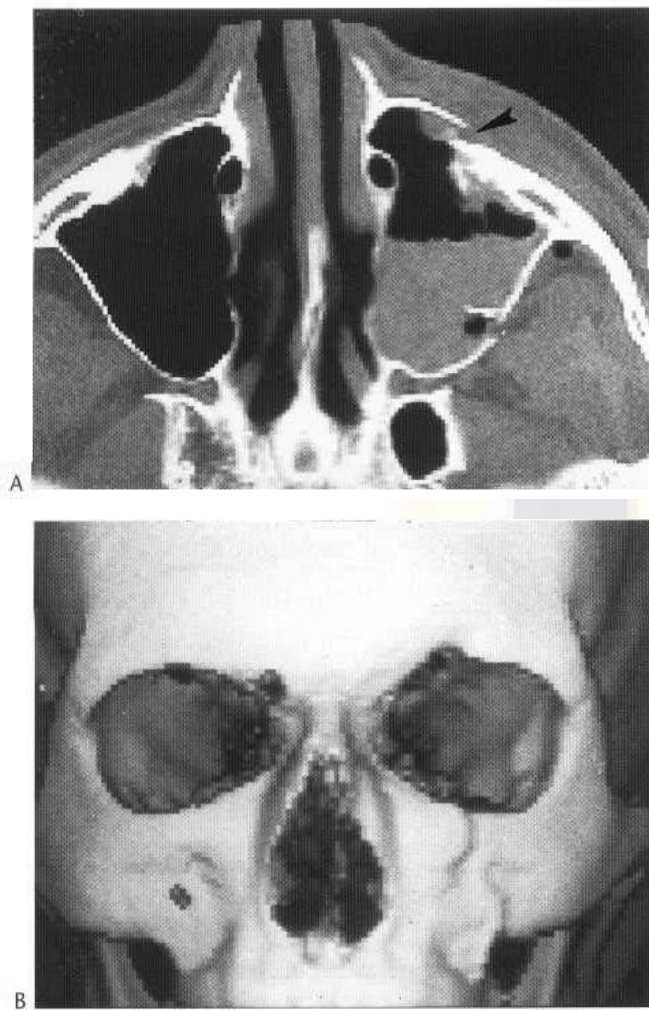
(A) CT scan demonstrates an air-fluid level in the left maxillary antrum, and a fracture of the anterior wall (arrowhead). (B) 3D reconstruction of the face, showing the fracture.
